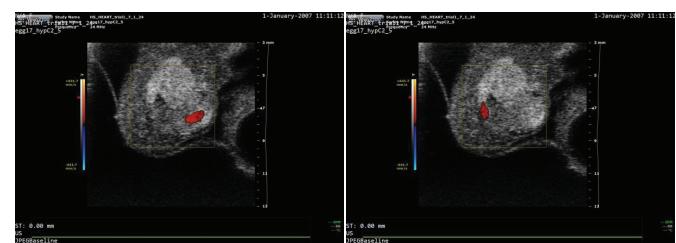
Colored Doppler images. Red indicates blood flow toward the transducer. Blue indicates blood flow away from the transducer. Shows imaging angle for reproducible results. Shows which heart valves were measured to achieve velocity measurements.
